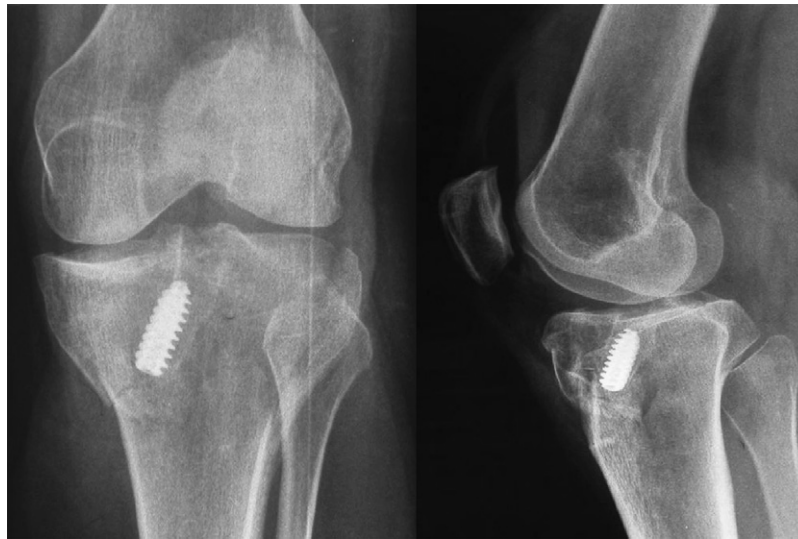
Plain radiograph demonstrating a complex bi-condylar fracture involving the tibial tunnel post ACL repair.
